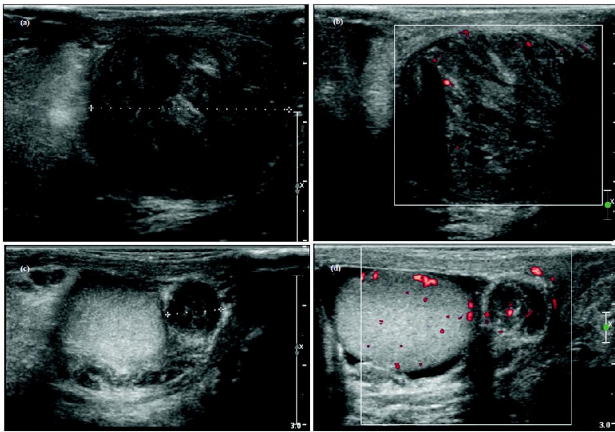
(a) Grayscale ultrasound image shows a 3.0 x 2.7 x 3.4 cm well-defined heterogeneous hypoechoic roundish solid lesion in left epididymal tail. (b) Doppler ultrasound study shows mild intralesional vascularity. (c) Right epididymal lesion with similar sonographic features as left sided lesion. (d) Mild vascularity is also noted in right epididymal lesion.
